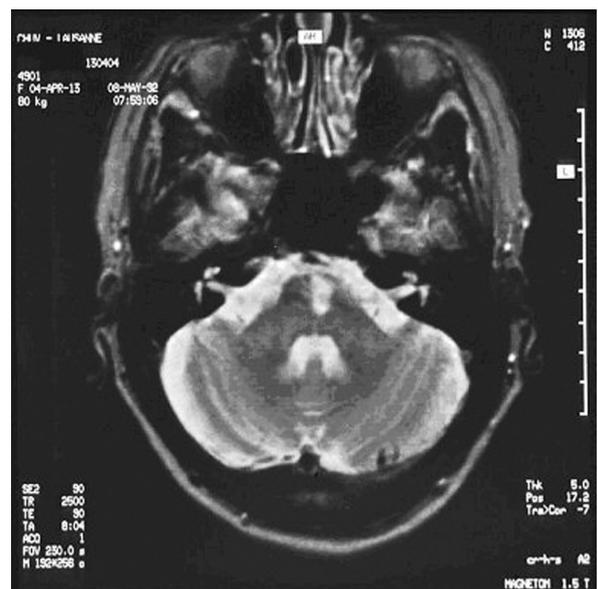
Caudal basal pontine infarction (MRI T2-weighted image).
